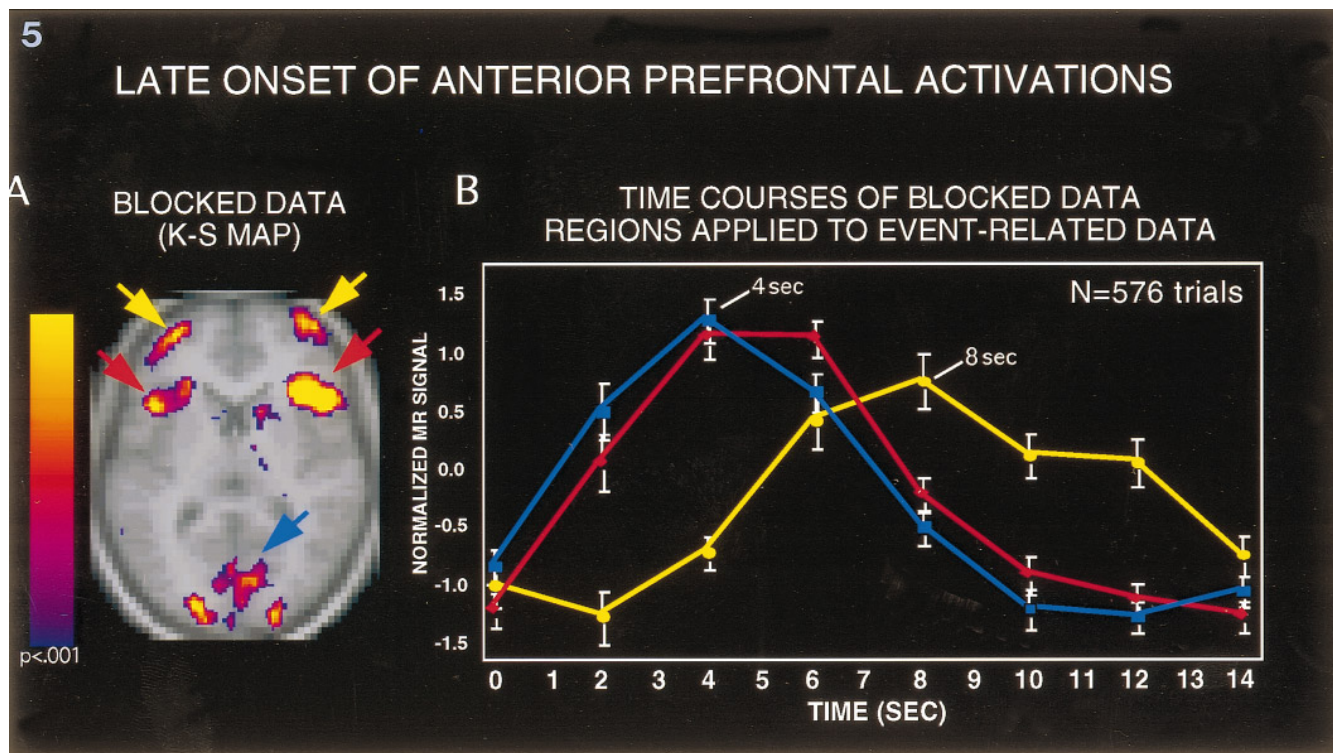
A K-S statistical activation map from the blocked trial data is shown on the left. This map is from a section containing the anterior prefrontal activations (yellow arrows), frontal opercular activations (red arrows), and visual cortex activations (blue arrow). To determine the time-course of these activations in the event-related runs, regions were defined around the activations in the blocked trial runs and then examined in the event-related data (similar to the procedure of Buckner *et al.*, 1996a). All regions were contained on a single slice so as to remove contributions from differential MRI slice acquisition times. The graph in the right panel shows the results, with anterior prefrontal activations peaking later and lasting considerably longer than the frontal opercular and visual cortex activations.
